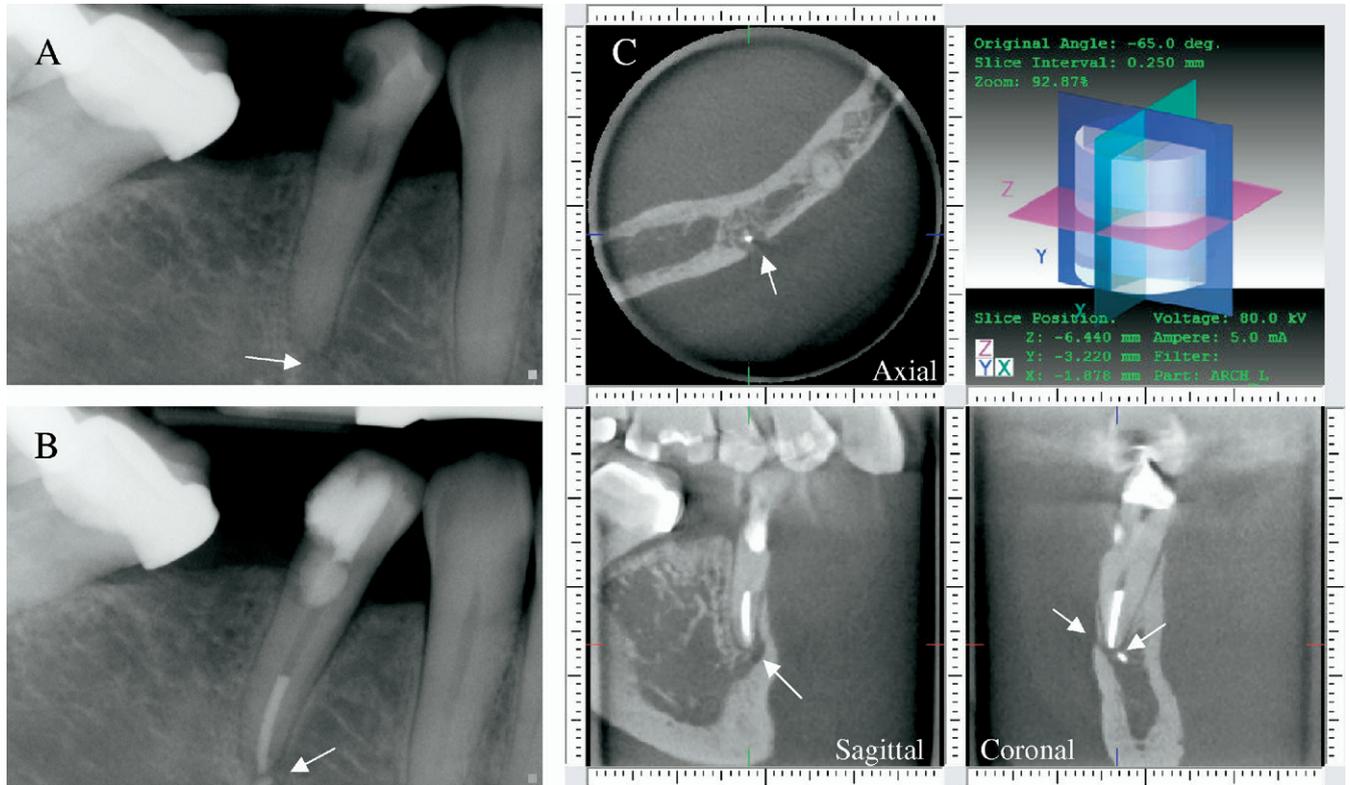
(A) Preoperative periapical radiograph depicts the proximity of the mental foramen to the apex of #29. (B) Postoperative periapical radiograph shows the obturated root of #29 with extruded material beyond the apex. (C) CBVT taken 2 weeks postoperatively demonstrates axial, sagittal, and coronal 2-D slices of the mental foramen as it exits the cortical plate and its proximity to the apex of #29. In addition, the extruded material is visualized to be superior to the mental nerve.
